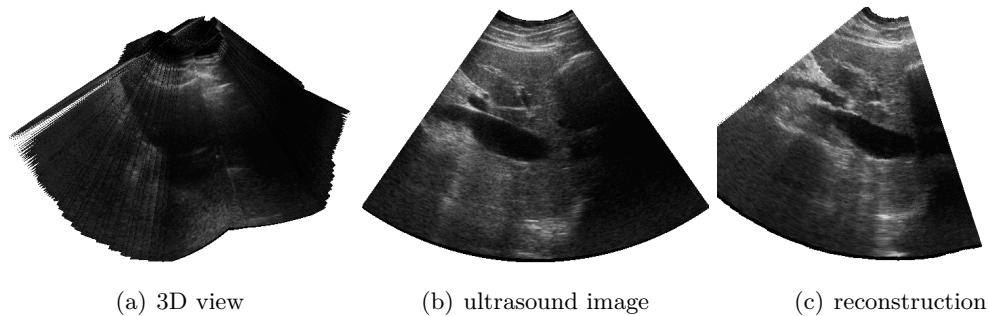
Freehand ultrasound sweep of the human liver. NCC for the shown images is 0.60.
